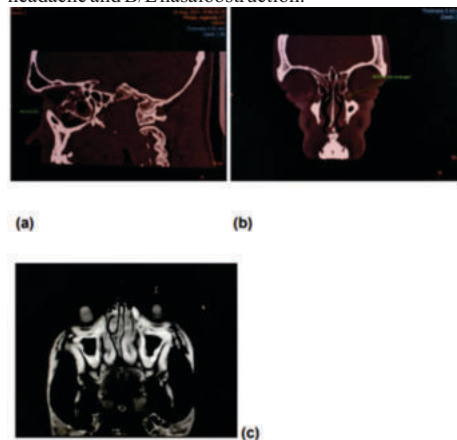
(a-c) : LT.Dacryocystitis. (a-b) sagittal and coronal CT-ORBITS showing hypodense fluid collection at medial canthus of left orbit involving lacrimal sac. (d) axial T2w MR image showing hyperintense fluid collection at medial canthus involving lacrimal sac with mucosal thickening involving B/L maxillary sinus.
